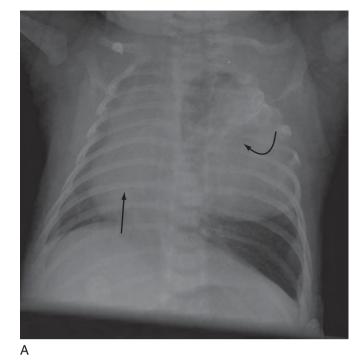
Utility of magnetic resonance imaging: 25-day-old boy with a chest wall mass. Radiograph (A) demonstrates a large left chest wall mass (*curved black arrow*) deviating the heart to the right side (*black arrow*). On an axial T2-weighted sequence (B), the excellent spatial resolution of MR imaging allows differentiation of the mass (*black arrow*) from the thymus (*curved black arrow*), the trachea (*curved white arrow*), and the aortic arch (*white arrow*).
